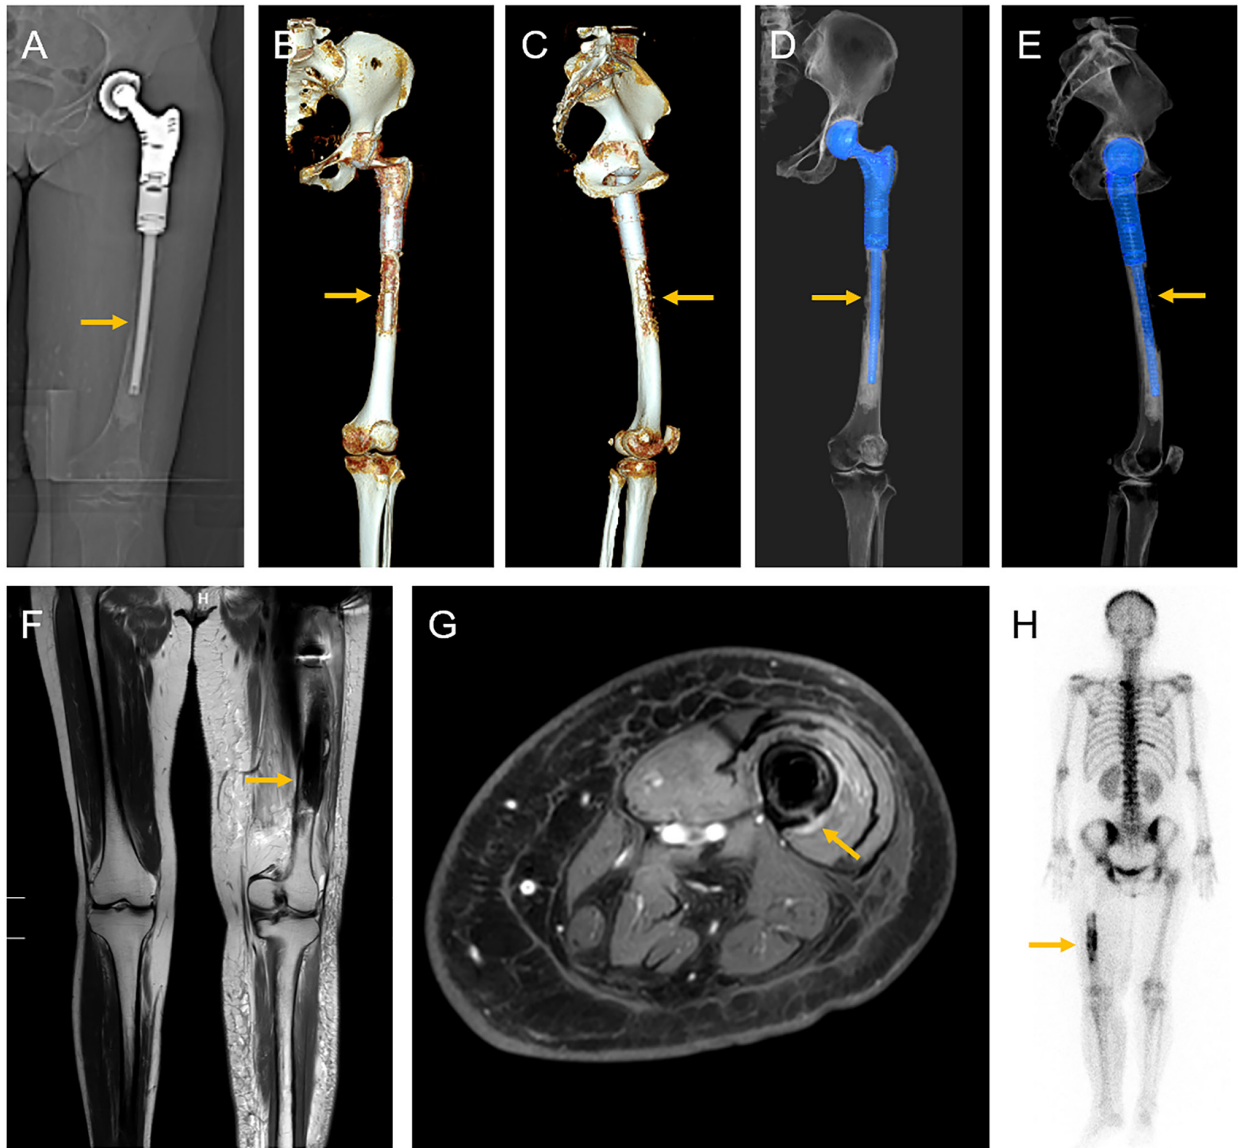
Preoperative imaging findings (June 2024). (A) X-ray showed osteolytic destruction of the distal femur around the primary prosthesis. (B) Coronal 3D CT reconstruction demonstrating distal femoral bone destruction (arrow). (C) Sagittal 3D CT reconstruction confirming prosthetic loosening and periprosthetic bone resorption (arrow). (D) Coronal 3D CT with segmented blue-colored prosthesis visualizing prosthetic loosening (arrow). (E) Sagittal 3D CT with segmented blue-colored prosthesis demonstrating prosthetic migration (arrow). (F) Sagittal MRI showing abnormal signal intensity in the distal femur and periprosthetic soft tissue (arrow). (G) Axial MRI revealing periprosthetic fluid collection and soft tissue edema (arrow). (H) Single photon emission computed tomography bone scan revealing abnormal radionuclide uptake in the left femoral stump (arrows), as well as in T2, T5 and T7 vertebrae.
